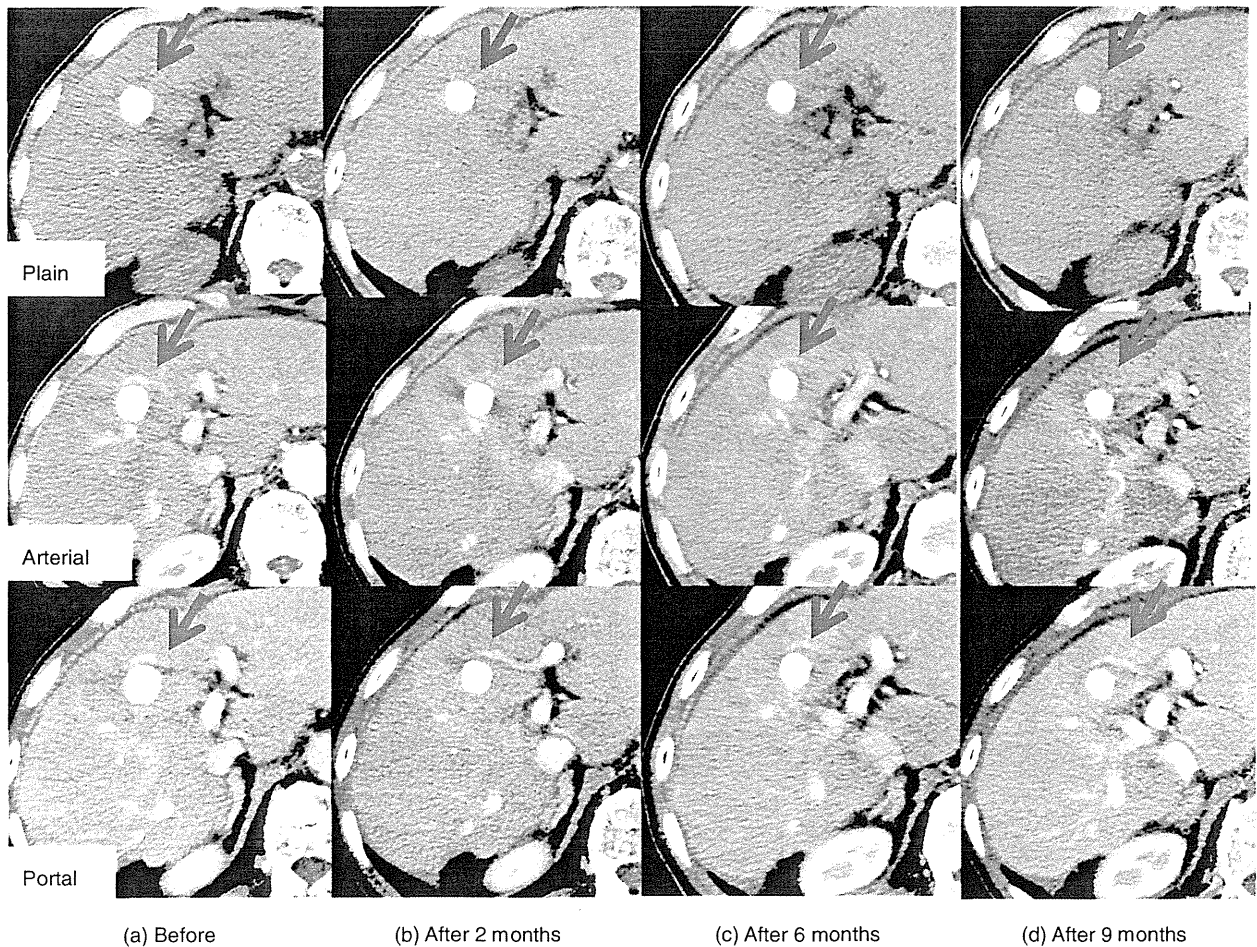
Dynamic computed tomography appearance of tumor response type 1 (plain, arterial and portal phase in case 37). (a) Before stereotactic body radiation therapy; (b) 2 months after; (c) 6 months after, and (d) 9 months after. Note the continuous presence of dense lipiodol accumulation without early arterial enhancement in all phases (red arrow).
